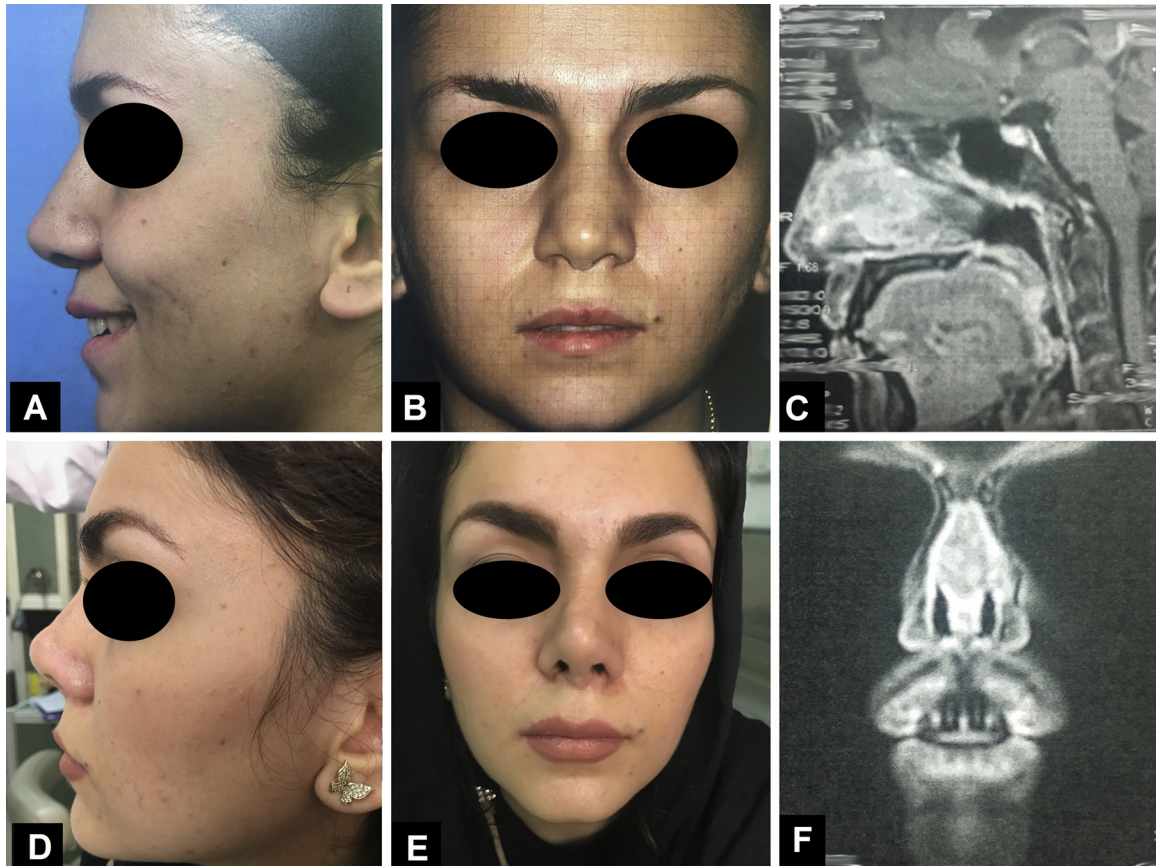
Case patient 2: (A) lateral photograph obtained preoperatively; (B) frontal photograph obtained preoperatively; (C) sagittal T1 enhanced MRI; (D) lateral photograph obtained at 8 months postoperative; (E) frontal photograph obtained at 8 months postoperative; (F) coronal T1 enhanced MRI.
